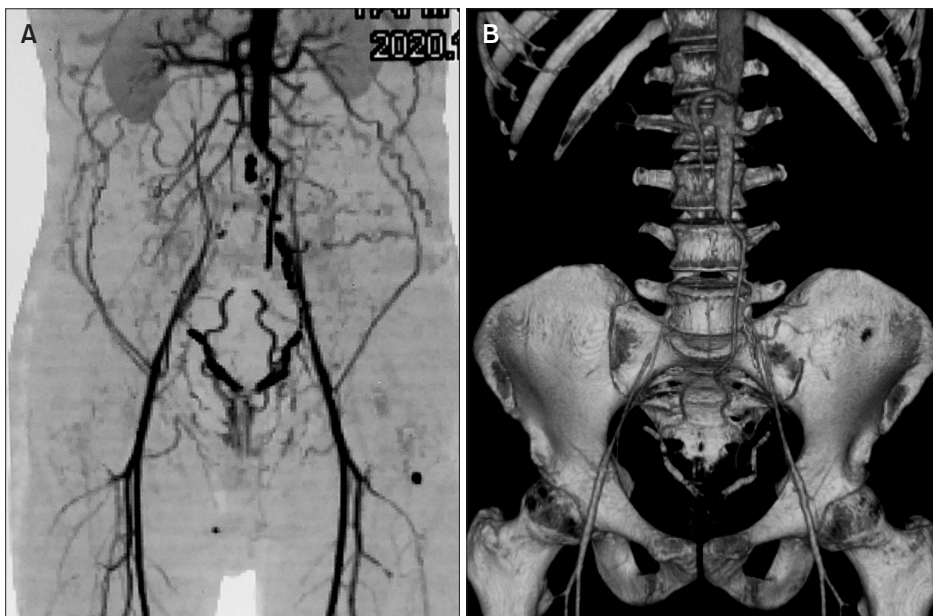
(A) Preoperative computed tomography angiography (CTA) showed extensive occlusion of the distal aorta and both common iliac arteries. The collaterals were filling the external iliac arteries on both sides. (B) A 3-dimensional reconstructed CTA showed the aortoiliac occlusion.
